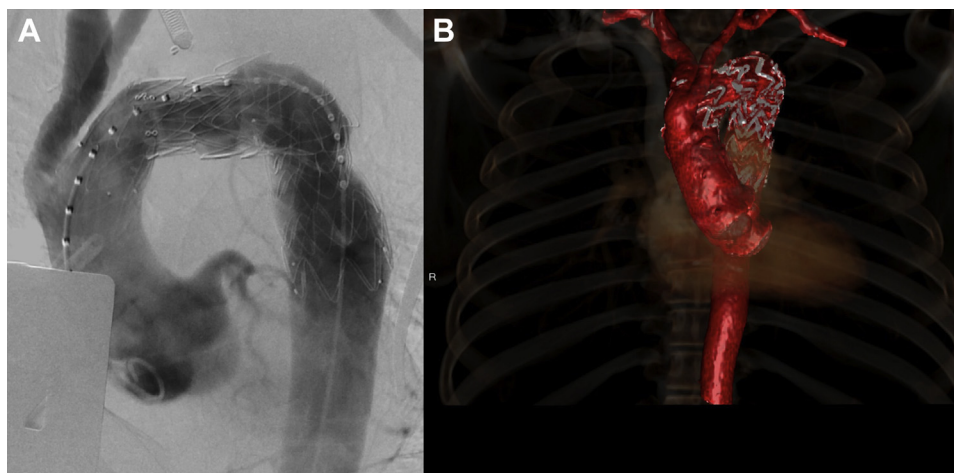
Completion aortography after removal of the ascending aortic sheaths and securing of cannulation sutures via a transfemoral pigtail catheter (A) and immediate postoperative computed tomography angiogram reconstruction (B) demonstrating successful zone 0 thoracic endovascular aortic repair placement without evidence of endoleak and exclusion of left subclavian aneurysm with good arch debranching and supra-aortic trunk flow.
